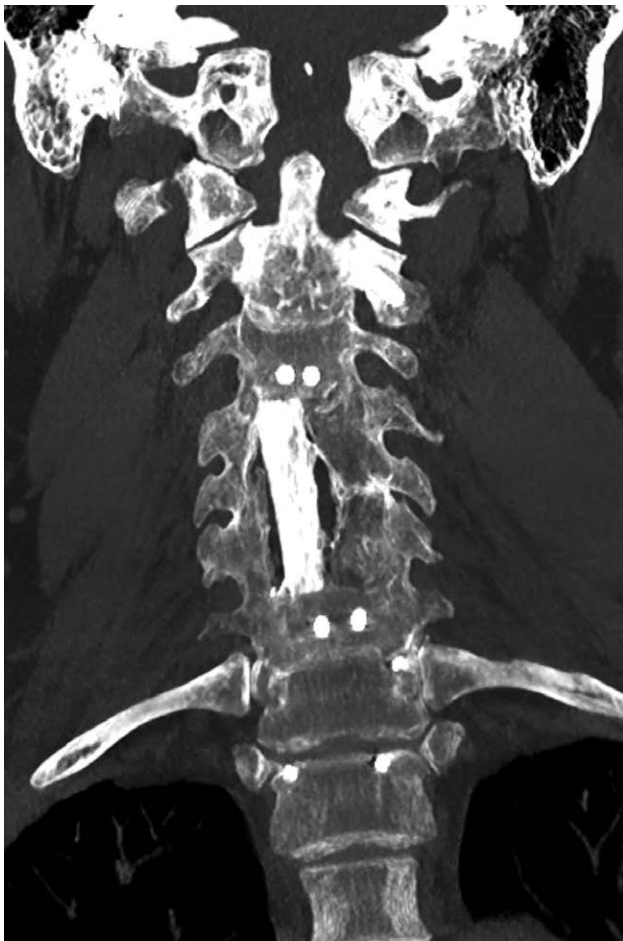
The CT scan image showing the coronal projection of the FVFG fixated with the anterior plate after 5 years.
